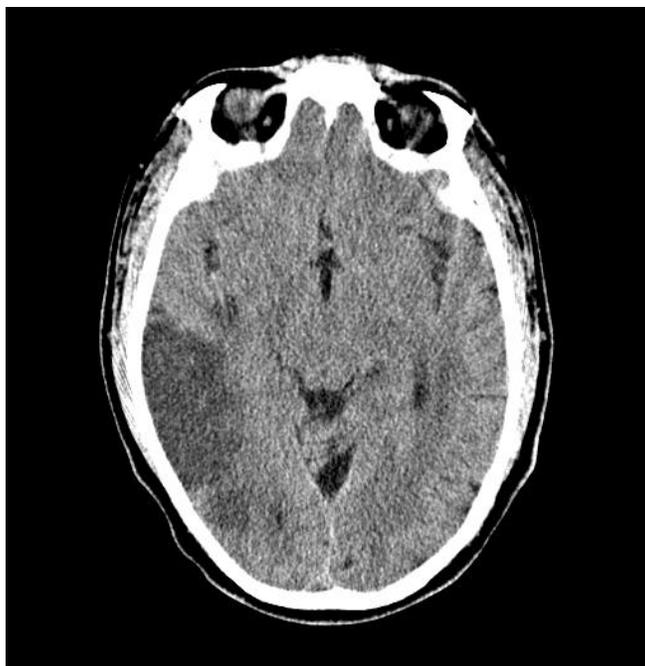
CT scan of the brain, anonymized patient, Toronto, 2010. On a CT scan, air is black, bone is white, and brain is grey. The head is oriented such that the eyes are at the top and the back of the head is at the bottom of the image. An area to the back left that is darker grey represents an ischemic stroke affecting the right middle cerebral artery territory. The fact that the brain in this section is darker than the rest suggests that it is irreversibly damaged.
